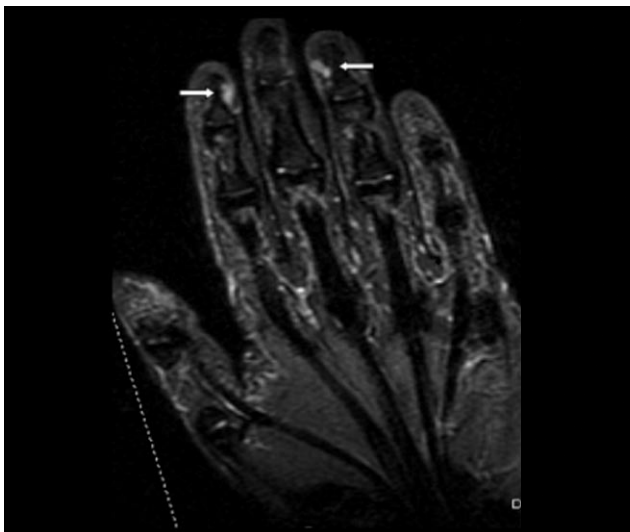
Contrast-enhanced T₂-weighted magnetic resonance imaging of left hand shows bright enhancement of index and ring finger masses.
